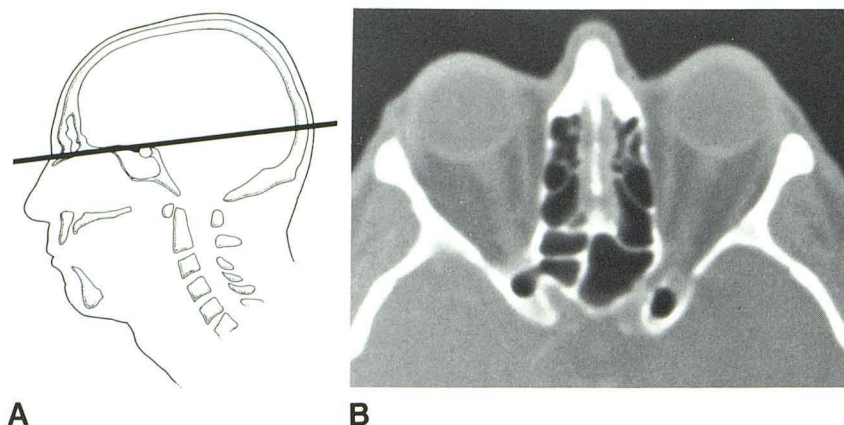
A, Optimal angle of plane for visualization of cribriform plate and pterygomaxillary space. B, CT scan obtained using this reference line demonstrates visualization of soft tissue just above cribriform plate with ethmoid air cells lying just lateral to cribriform area.
